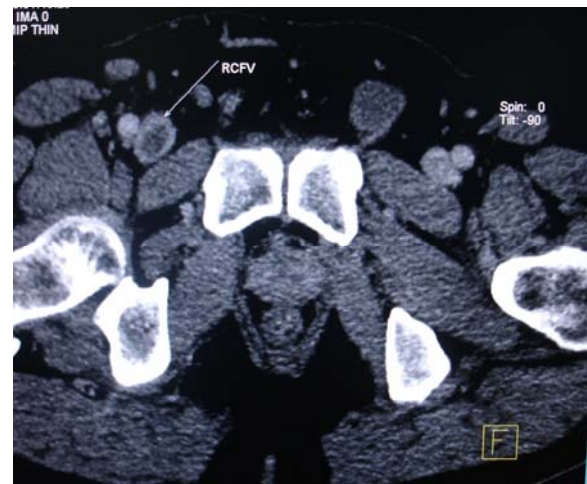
CT angiogram- Axial image showing central non-enhancing thrombus (arrow) in right common femoral vein. Left sided vein is thrombus free.
